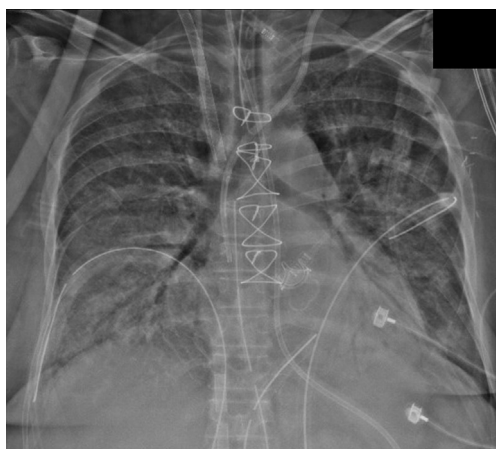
Post-operative chest X-ray with pulmonary edema followed by VV-ECMO and CVVHD catheter cannulation. VV-ECMO, veno-venous extracorporeal membrane oxygenation; CVVHD, continuous venous-venous hemodialysis.
